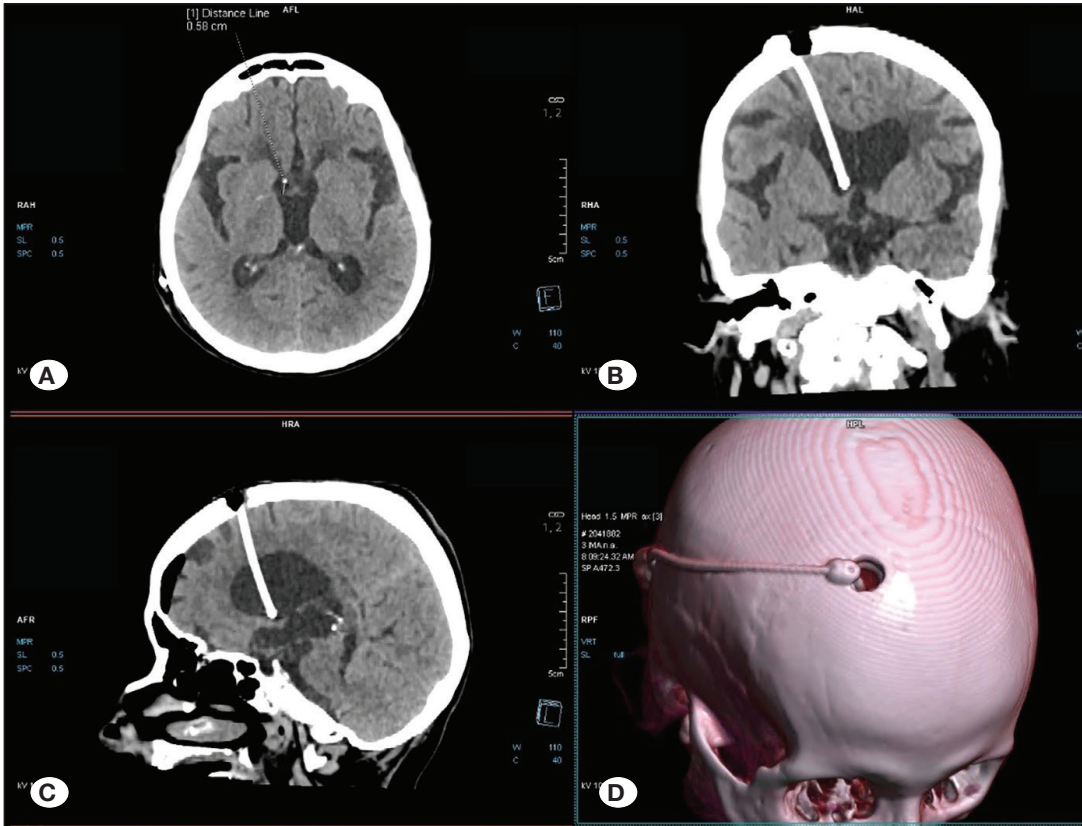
Postoperative axial (A), coronal (B), sagittal (C) and 3-D (D) computed tomography scans. We can see AxiEM guidance ventricular catheter placement on the desired location just behind to foramen of Monro.
